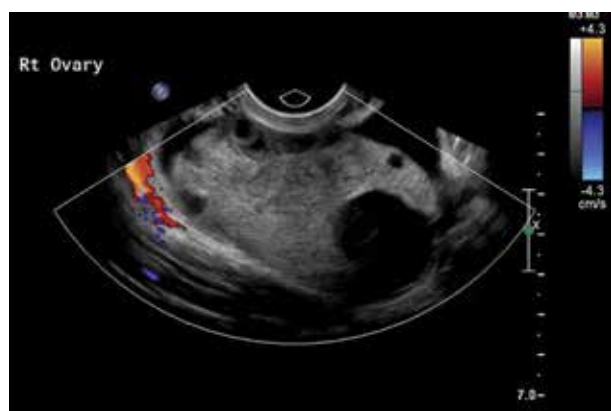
Ovarian torsion. Transvaginal ultrasound image demonstrating an enlarged ovary with peripherally displaced follicles, mild increased central echogenicity and absence of colour flow.
